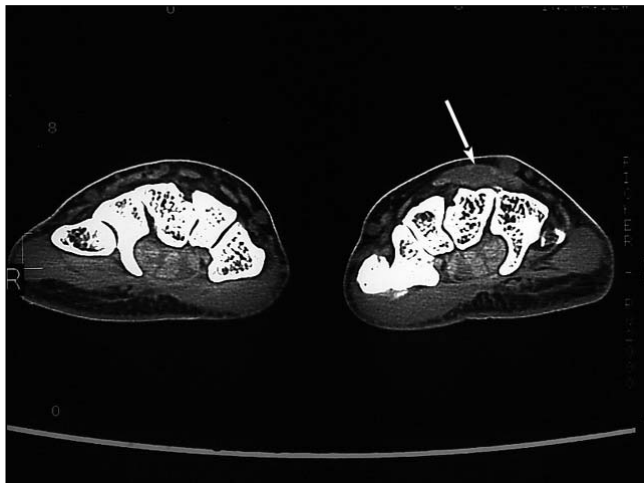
Axial CT of both wrists. Asymmetric soft tissue attenuation "mass-like" area at the dorsal aspect of the left wrist (white arrow)
